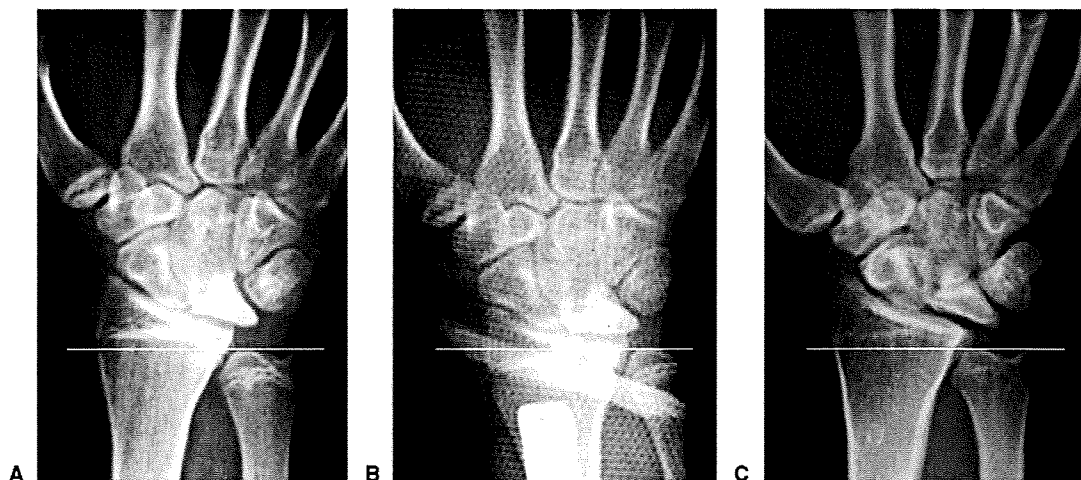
A A preoperative AP radiograph of a 13-year-old boy shows Stage IIIB Kienböck's disease in the right wrist. B The AP radiograph immediately after radial shortening reveals 1-mm ulna-negative variance. C Radial overgrowth at the affected side is found in the AP radiograph at 65 months after radial shortening. The transverse line is set on the tip of ulnar head in A–C.
